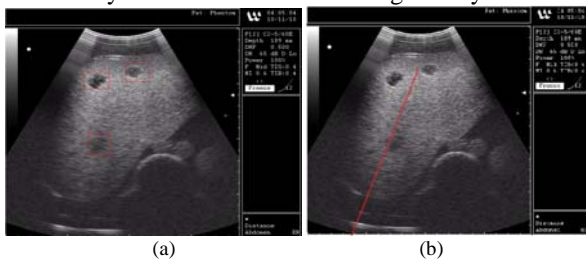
Intraoperative ultrasound image. (a) Renal stones in the ultrasound slice. (b) Corresponding puncturing point and path in ultrasound slice.
